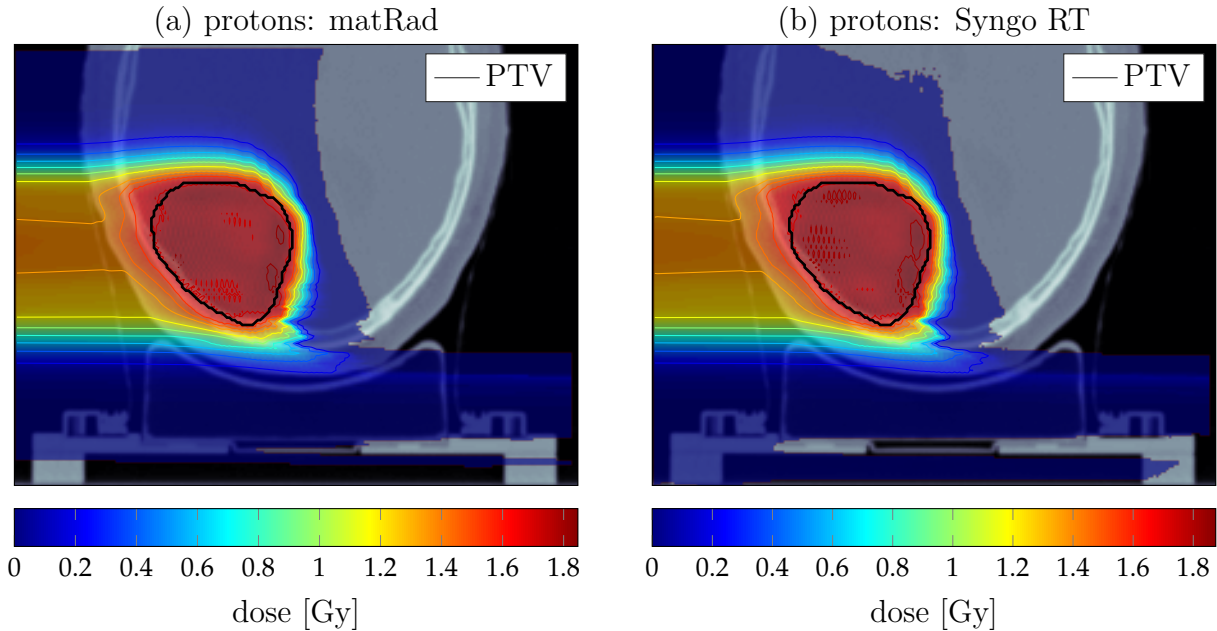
Transversal CT slices of the clinical cranial case. The CT is superimposed with transparent dose colorwash, solid iso dose lines and a solid black contour (—) denoting the PTV. The dose is given in [Gy] and originates from an intensity-modulated single beam proton therapy treatment plan with gantry angle 270° and couch angle 0° .
